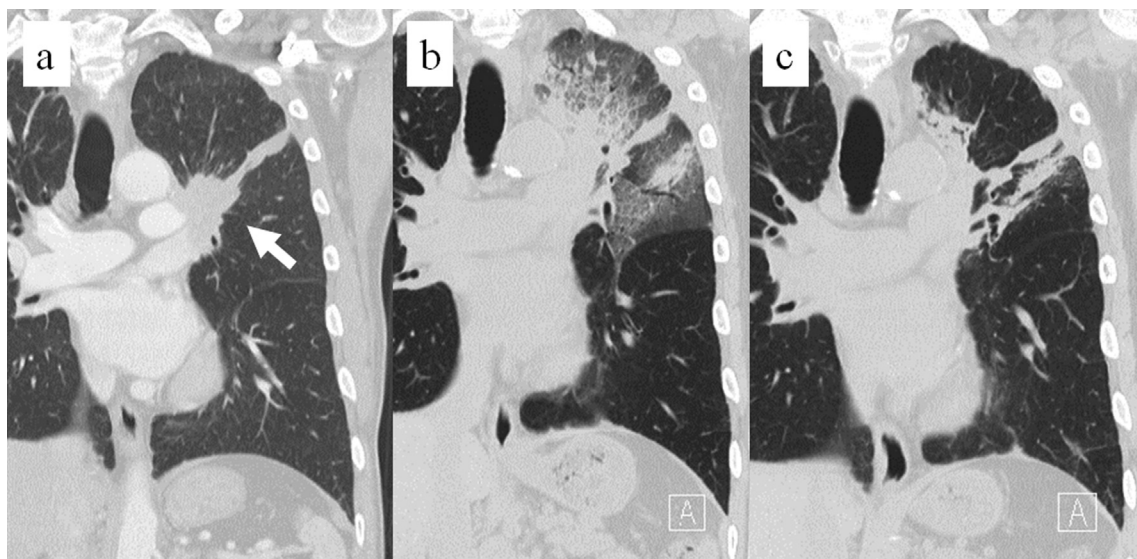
Chest CT in case 1. a) A tumor in the left upper lobe (arrow). b) Preoperative radiation pneumonitis. c) Inflammation of the lungs was improved with only residual fibrosis.
